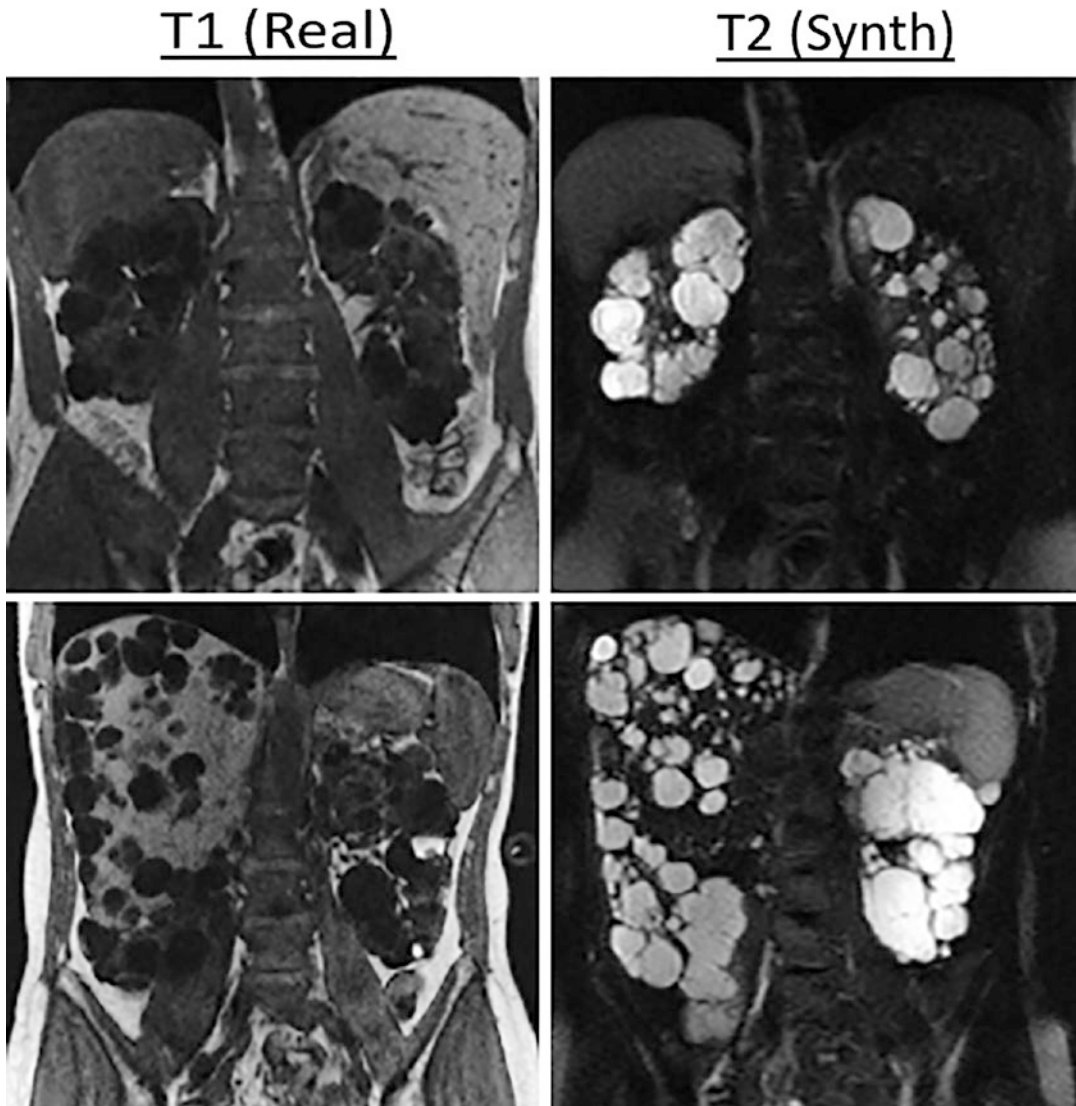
Examples of two real T1-weighted MR images and corresponding synthesized T2-weighted MR images. Reprinted from “Segmenting new image acquisitions
